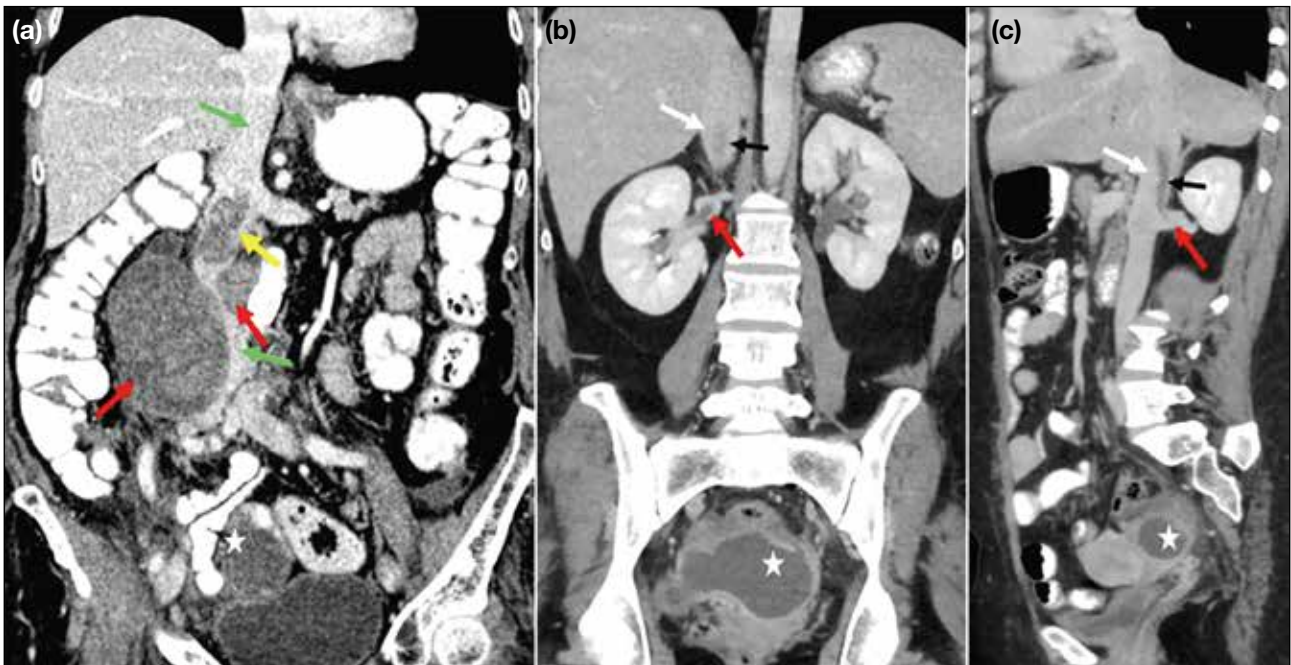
Two cases of ovarian cancer. (a) Coronal contrast-enhanced computed tomography (CECT) image of the abdomen of a 62-year-old patient shows right ovarian malignancy (star) with an intraluminal thrombus in the inferior vena cava (IVC) [yellow arrow] and extraluminal compression (green arrows) by enlarged lymph nodes (red arrows). (b, c) Coronal CECT images of the abdomen of a 53-year-old patient show a complex cystic lesion in the pelvis and left adnexa (stars), with bland thrombi (black arrows) in the infrahepatic IVC (white arrows) and the right renal vein (red arrows).
